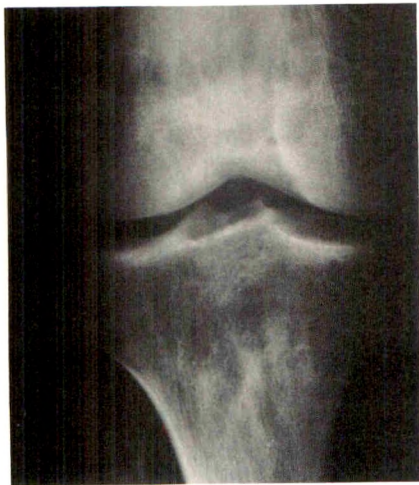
Immature bone infarct in a patient with sickle cell disease who had sudden onset of knee pain. Radiograph of knee shows patchy, mottled region of radiolucency with mild sclerosis of femur and tibia. Biopsy of tibia showed bone-marrow infarction.
